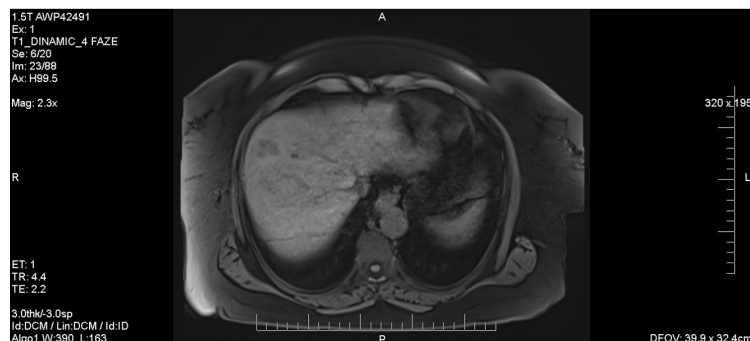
Abdominal MRI showing liver lesions in hypo-signal on T1 sequences. MRI: magnetic resonance imaging
